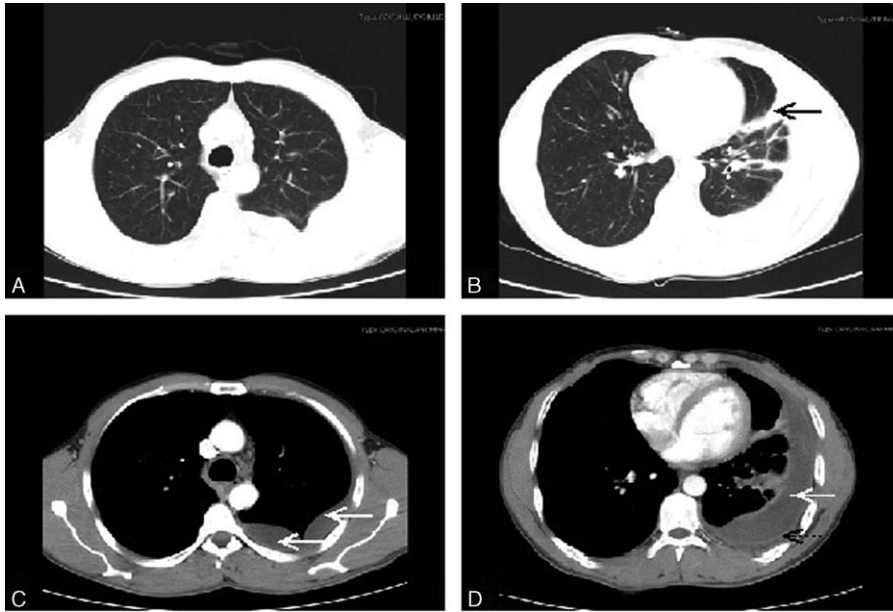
Chest CT findings. It showed patchy consolidation in ligule segment of the left lung (black arrow), atelectasis of the left lower lobe, multiple lymph nodes in the mediastinum, left pleural effusion (white arrow), and thickened left pleura (black dashed arrow). CT=computed tomography.
